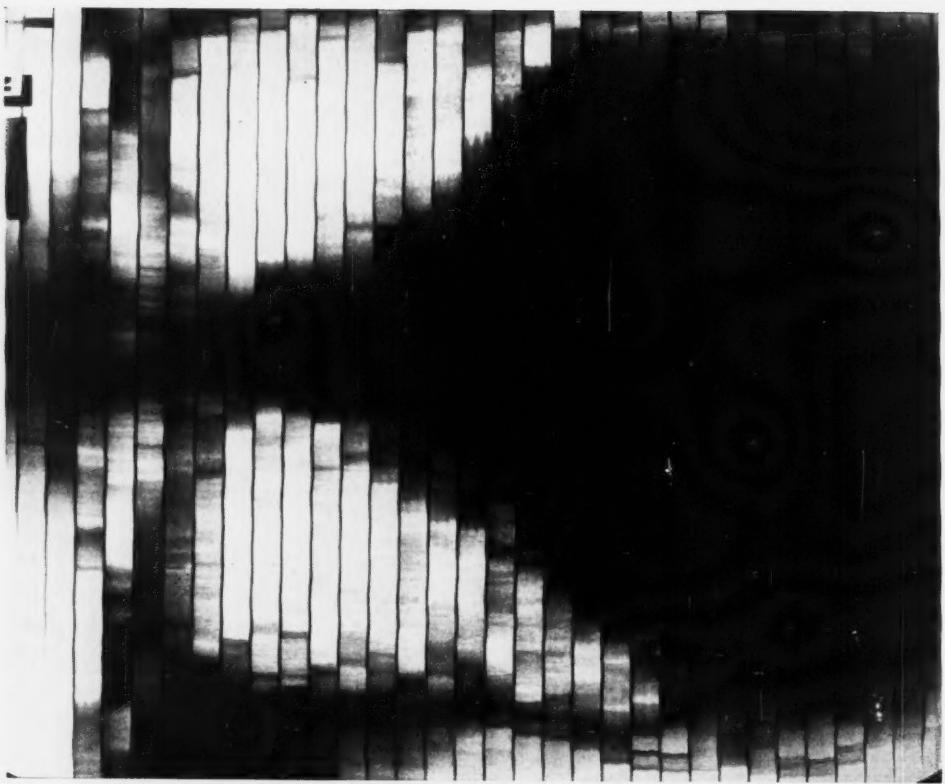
Case 2. Roentgenkymogram shows left ventricular enlargement with marked diminution of pulsation over lower half of left ventricular border.
